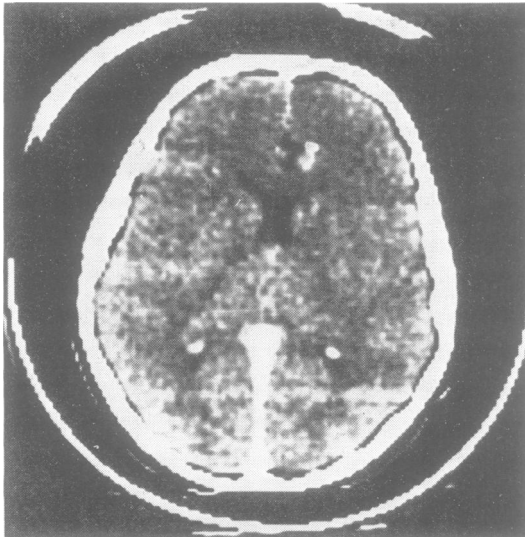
Figure Post contrast CT scan. The lesion is within the right cingulate gyrus and impinges upon the genu of the corpus callosum, partially obliterating the right frontal horn. Posterior to calcification, there is a small area of enhancement.
